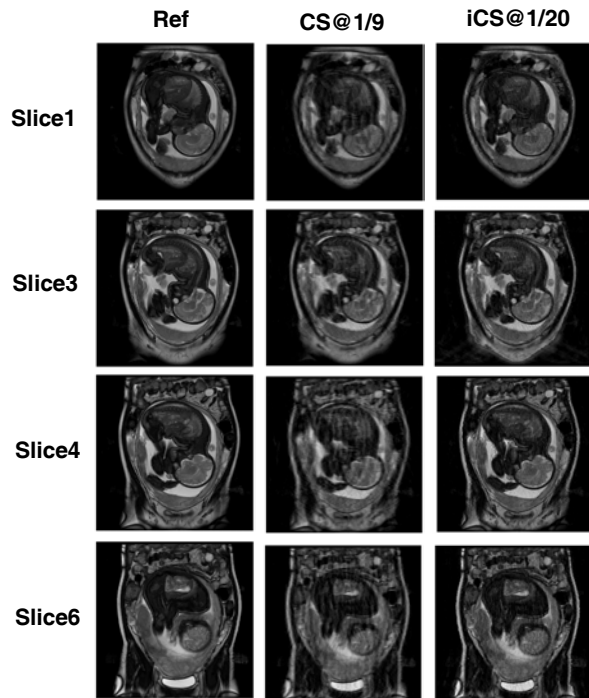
In-vivo MR images of fetus. The first column are reference images reconstructed from full k -space; the second column are images reconstructed using CS at 1/9 sampling rate; the third column are images reconstructed using proposed iCS method at the sampling rate of 1/20. The quality of the iCS reconstructed images is not worse than those of the CS reconstructed images.
